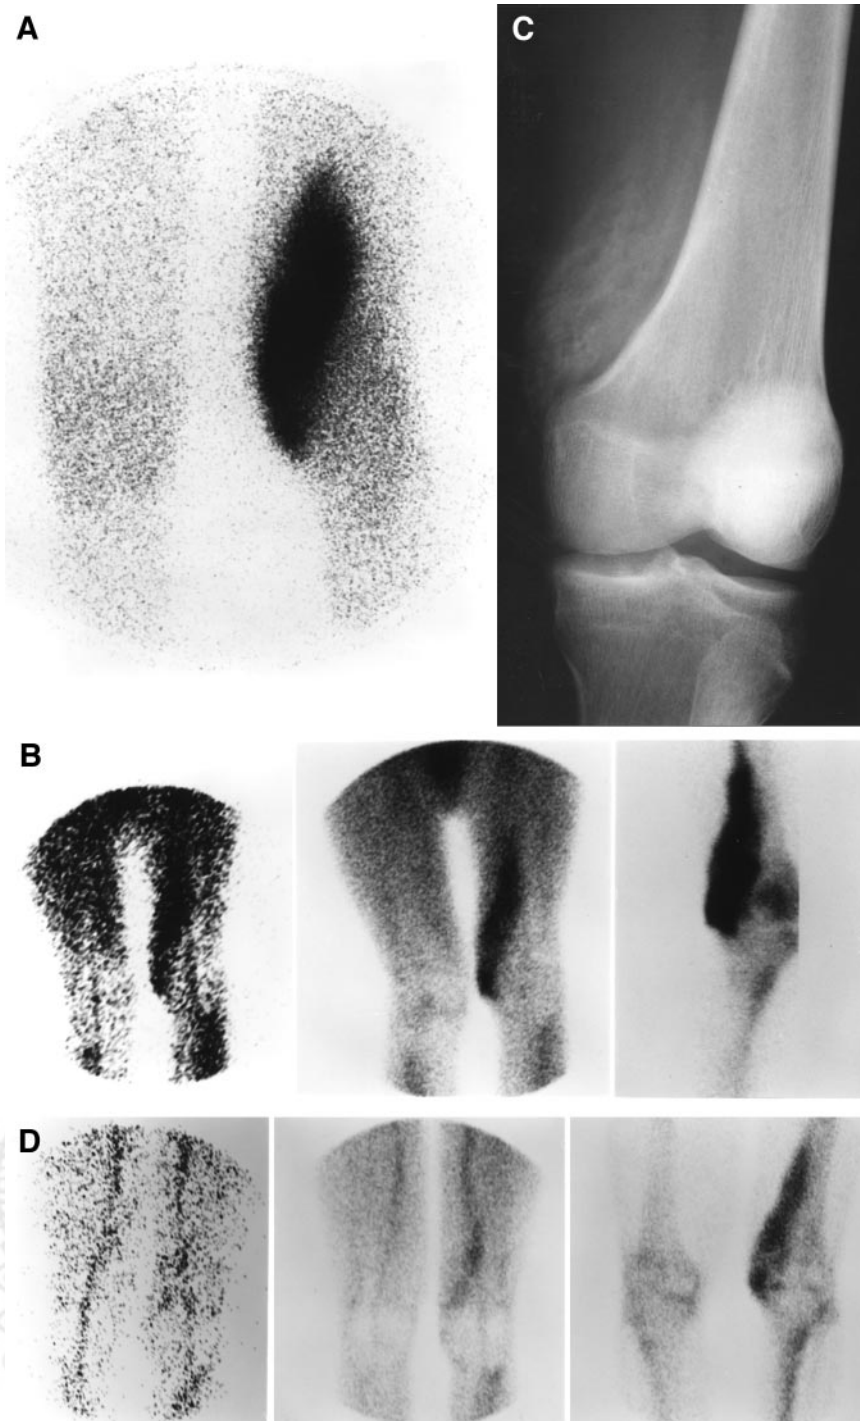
Fever (100.5°F) and left knee pain developed in 22-y-old man after closed cranial trauma, raising concern about osteomyelitis or other local infection. Initial radiography findings were normal. (A) ^{67}Ga image shows intense increased uptake in anteromedial aspect of distal left thigh. (B) From left to right, selected flow study images, blood pool images, and delayed bone scan images obtained shortly thereafter show increased flow, hyperemia, and increased uptake, respectively, also in anteromedial aspect of distal left knee. ^{67}Ga uptake is no more intense than is delayed $^{99\text{m}}\text{Tc}$ -MDP uptake, a finding favoring diagnosis of HO. (C) Subsequently obtained radiograph shows HO at this site. (D) Three-phase bone scan 18 mo after injury shows significantly less abnormal activity on (from left to right) flow study images, blood pool images, and delayed bone scan images. (Reprinted with permission of (58).)
